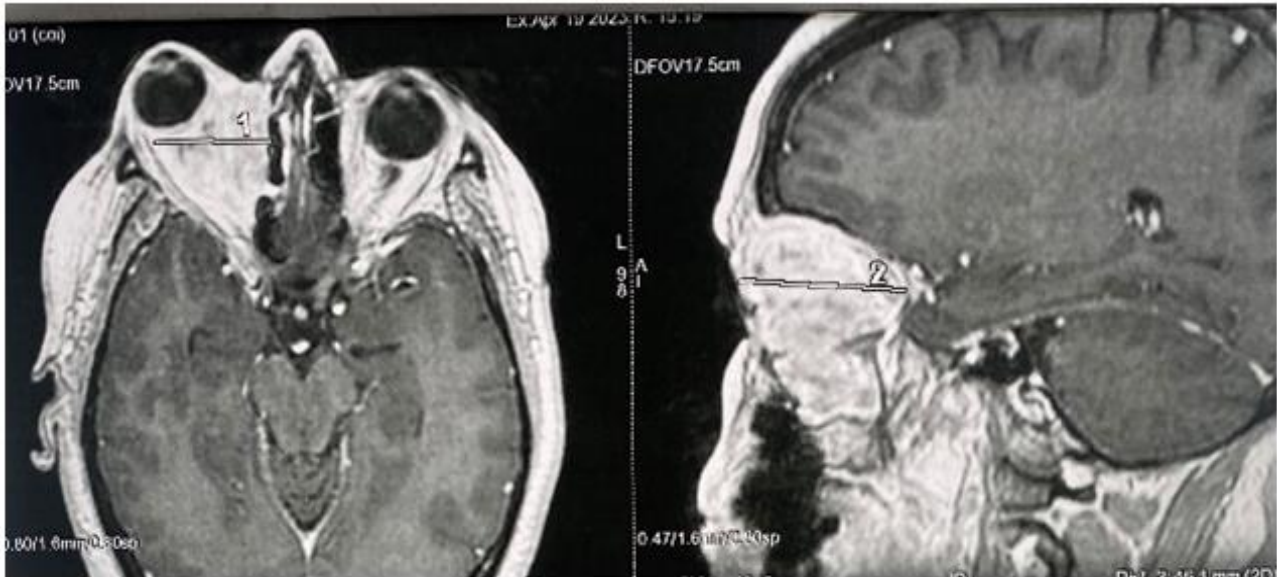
Facial MRI showing a neoplasm located in the medial portion of the orbit, entrapping the medial rectus and extending to the maxillary sinus
